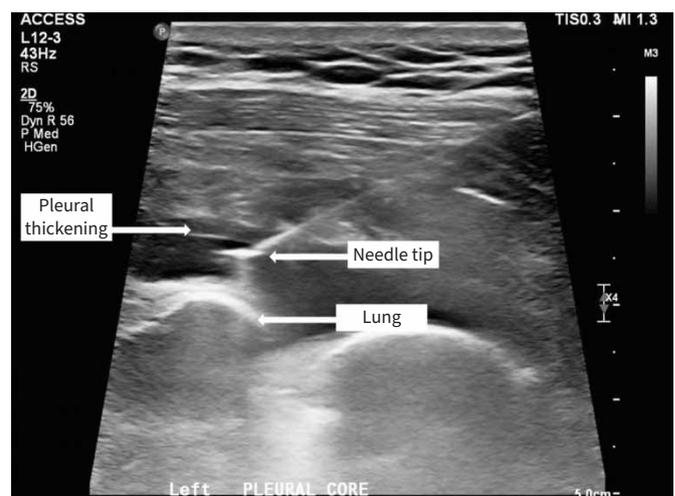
Real-time ultrasound-guided pleural biopsy.
